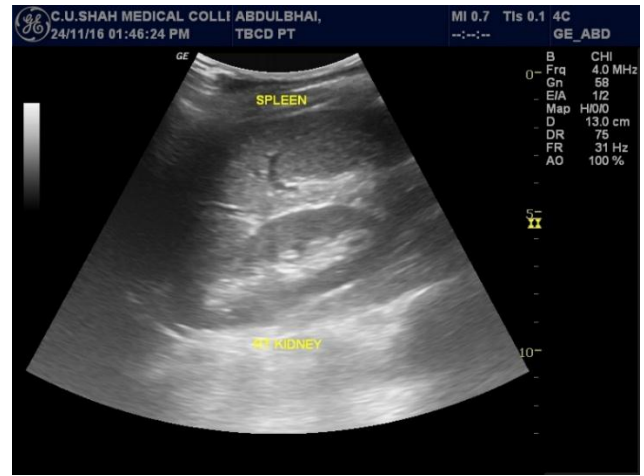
Ultrasound of abdomen.
